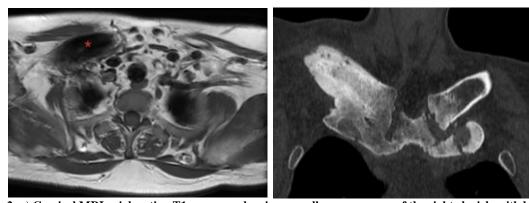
a) Cervical MRI axial section T1 sequence showing a swollen appearance of the right clavicle with loss of T1 hypersignal of the cancellous bone (star). b) CT scan of the thoracic bone window in coronal section, showing a hypertrophied aspect with osteocondensation of the right clavicle, the sternal manubrium, the sternoclavicular joints and the first sternocostal joints, with some lytic areas.
